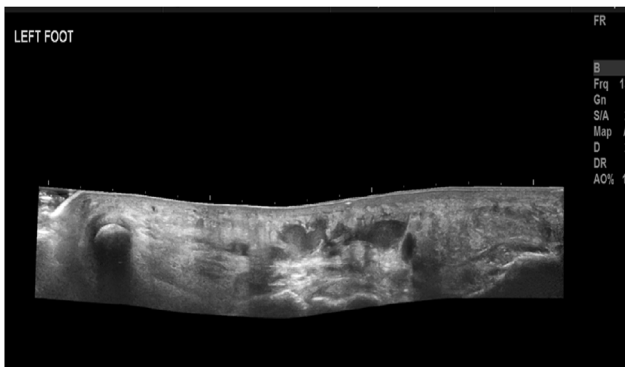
Ultrasound picture.
